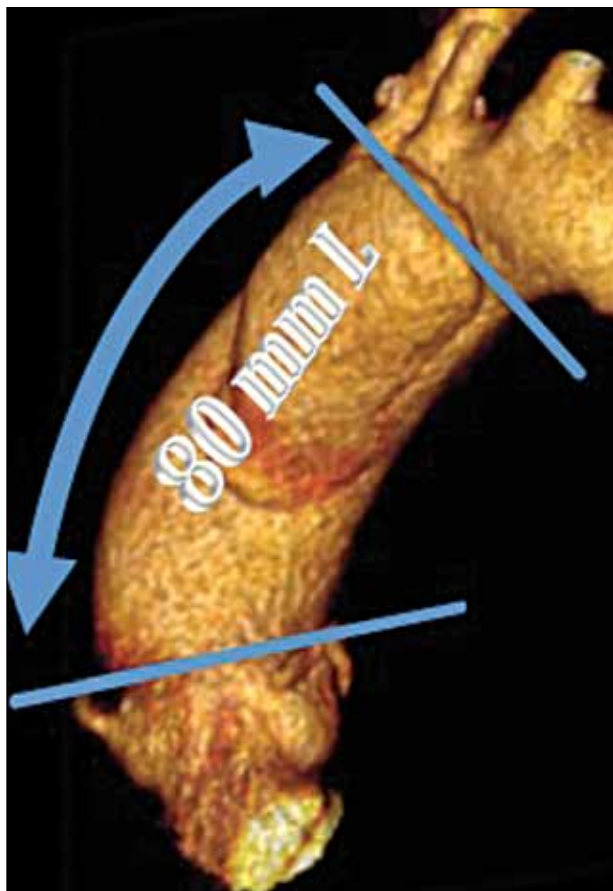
A preoperative CT scan showing 80-mm distance between the sinotubular junction and the brachiocephalic trunk.
